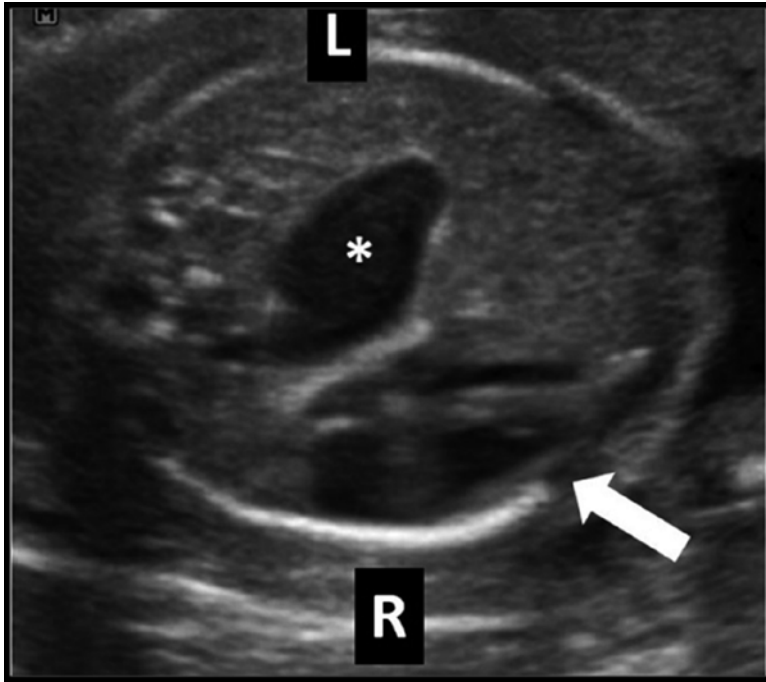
Axial ultrasound of the chest in a fetus with *left sided congenital diaphragmatic hernia*. The stomach (*) is present at the same level of the four-chamber view of the heart, and mediastinal shift with dextroposition is observed (*arrow*). *L* left, *R* right
